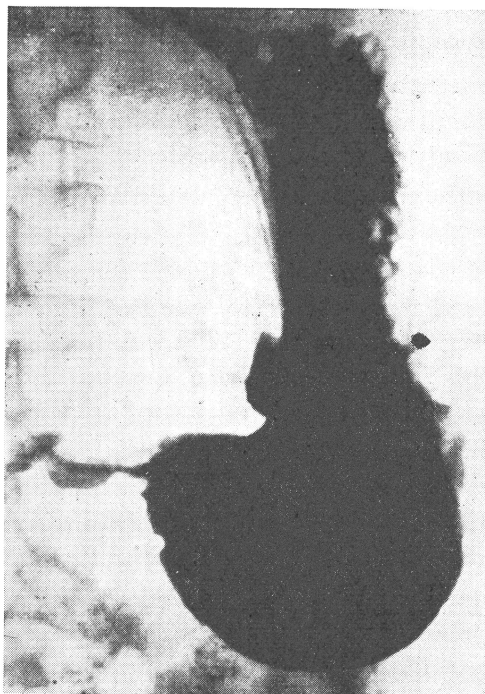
V. L., 66-year-old ♀. Gastric ulcer. Early X-rays
